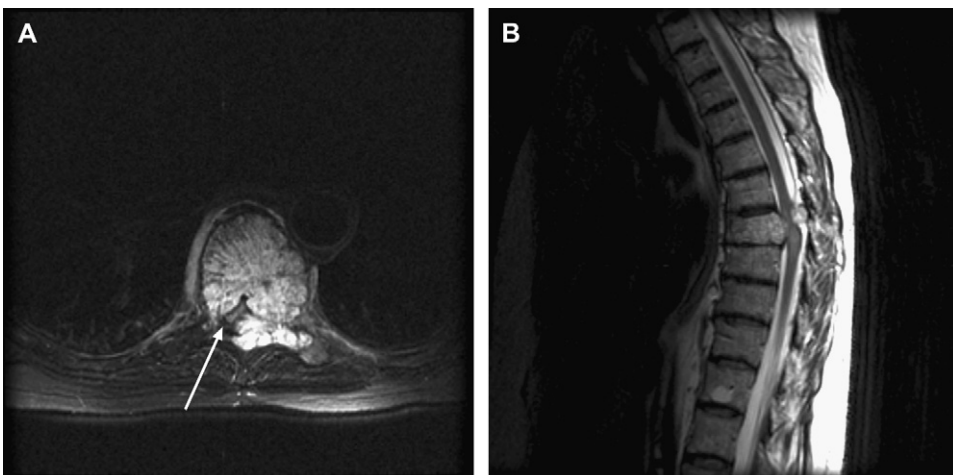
Axial (A) and sagittal (B) T2-weighted MRI through a T8 hemangioma shows extension into both pedicles, the left lamina and transverse process, and the left T8 rib. The associated vertebral body expansion and epidural extension results in severe circumferential cord compression with abnormal cord signal (arrow).
